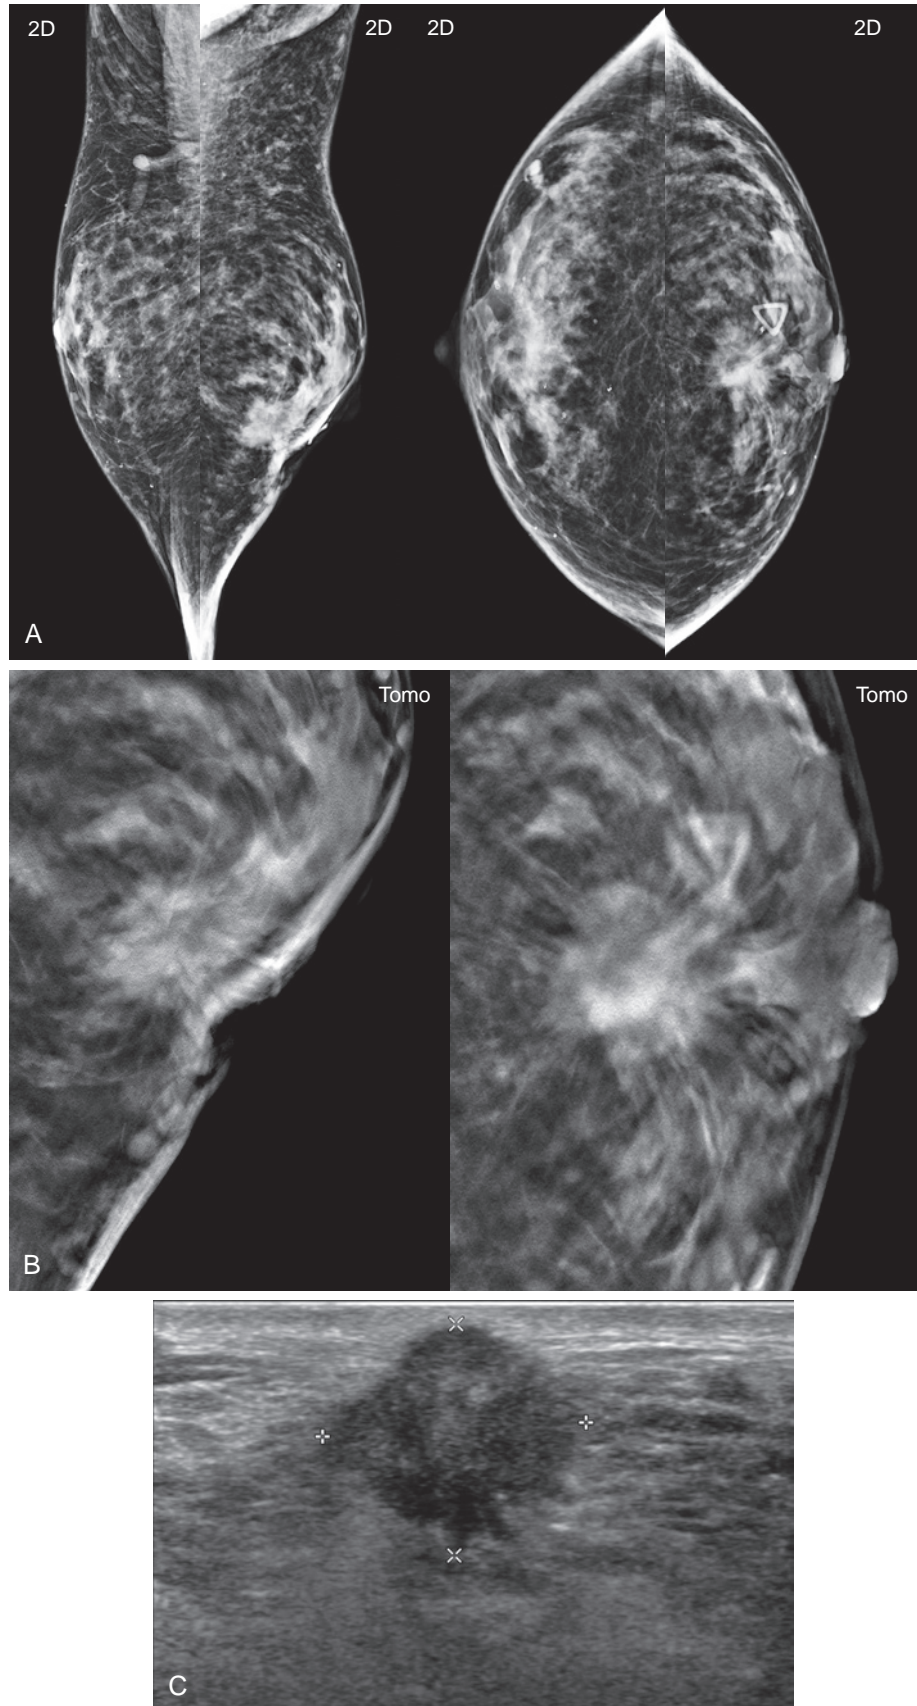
Breast cancer. An 82-year-old man presents with a palpable lump in the left breast. (A) 2D mammogram reveals diffuse gynecomastia bilaterally. A spiculated mass corresponding to the palpable finding is noted in the inferior left breast, with associated skin thickening and retraction. (B) Tomosynthesis mediolateral oblique and craniocaudal slice images demonstrate the extensive spiculations. (C) Ultrasound shows a corresponding 2.5-cm irregular mass with spiculated margin. Ultrasound-guided core needle biopsy showed poorly differentiated invasive and in situ ductal carcinoma, ER/PR+, Her2–.
